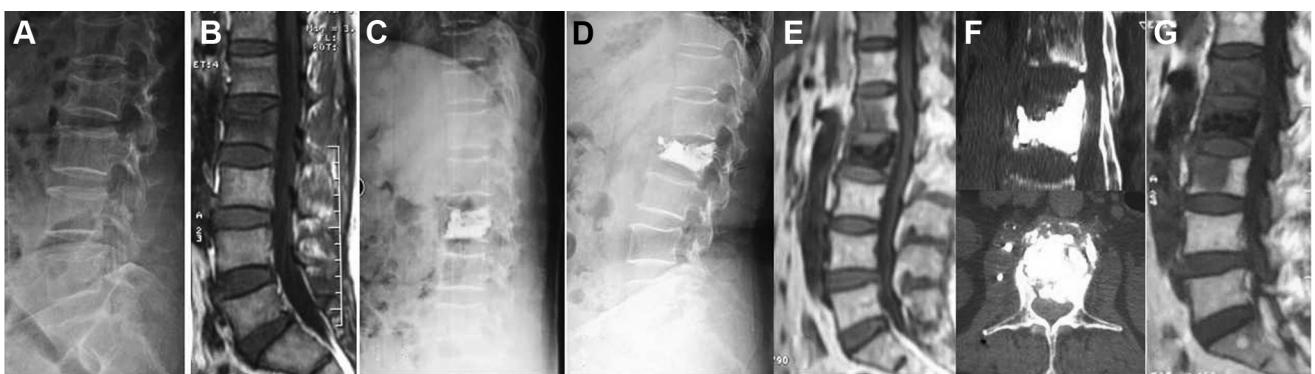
(A and B) Sagittal magnetic resonance imaging (MRI) and plain radiographs of a 68-year-old woman indicating vertebral compression fracture at the L2 level. (C) Surgical vertebral augmentation was performed. (D and E) About 3 months later, plain radiography and MRI showed severe spondylitis at the L1–L2 level, with bony destruction of L2. (F and G) After 12 days, computed tomography and MRI of the same patient suggested rapid progression of infective spondylitis involving the L2–L3 level, with more severe bony destruction of L2.
